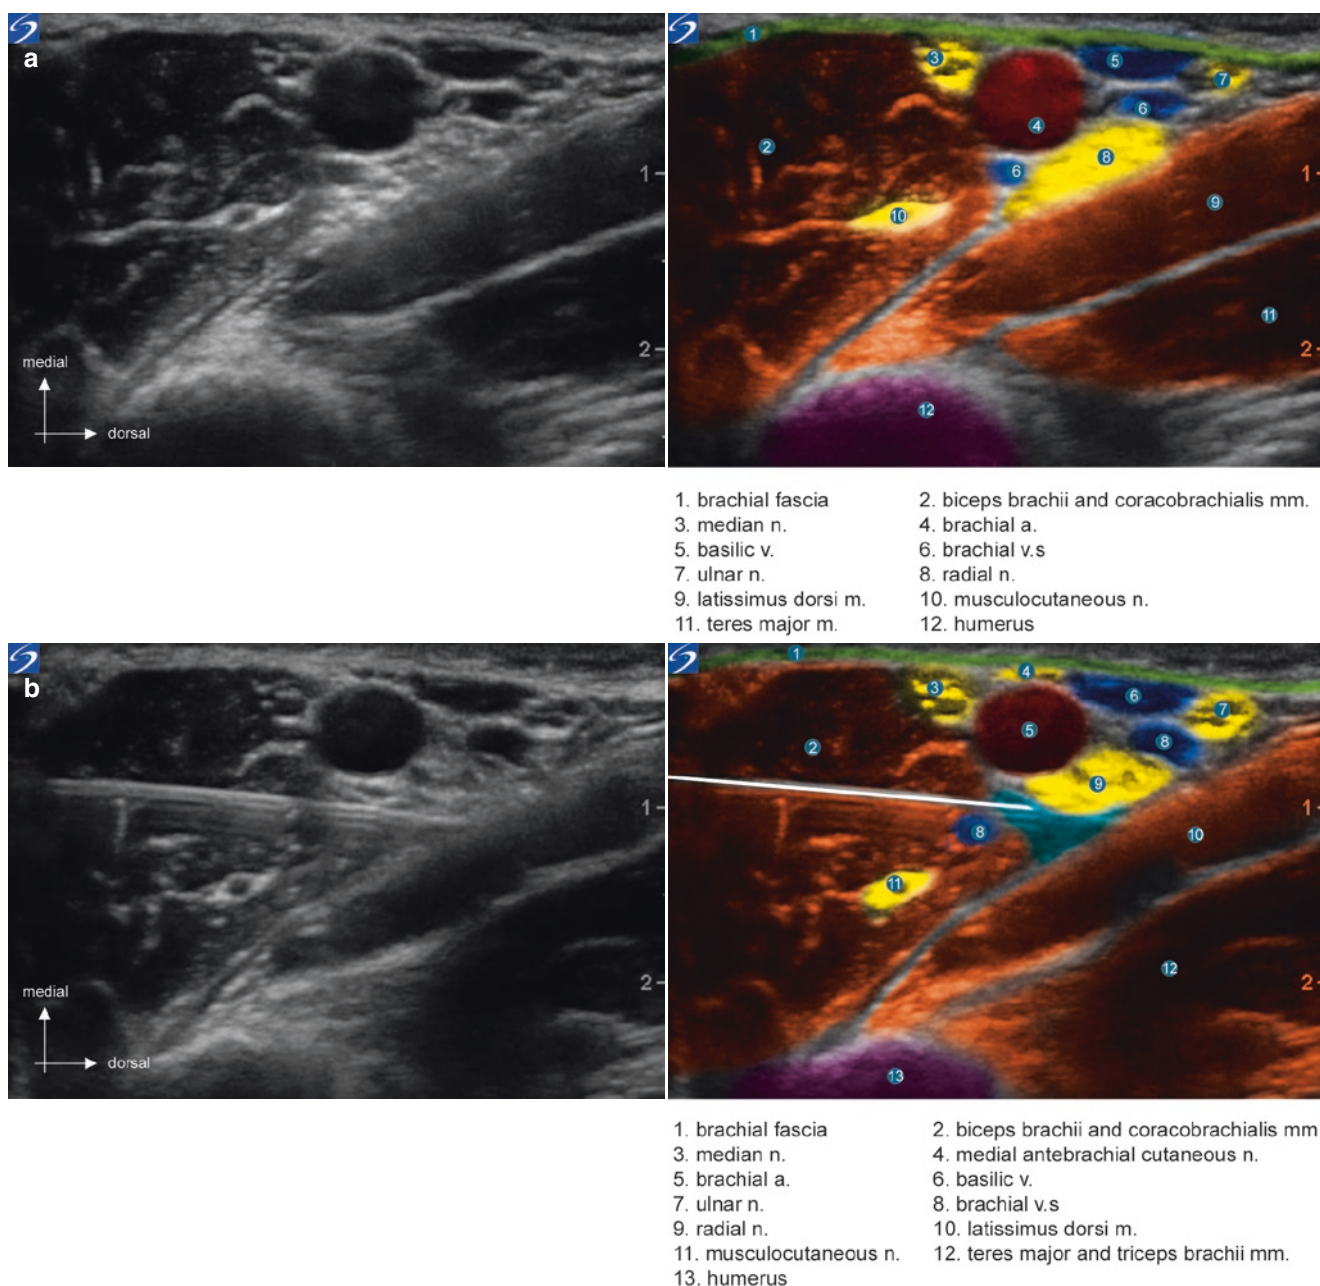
Ultrasound-guided axillary block performed using an in-plane approach. (a) Transverse sonoanatomical section in axillary area. (b) Axillary block. Tip of needle in contact with radial nerve. (c) Axillary block: initial injection of local anaesthetic in contact with radial nerve. (d) Axillary block. Spread of local anaesthetic around radial nerve. (e) Axillary block. Needle in contact with median nerve, progressing towards the ulnar nerve, with aid of hydrodissection. (f) Axillary block. Needle in contact with medial cutaneous nerve of forearm, progressing towards the ulnar nerve
